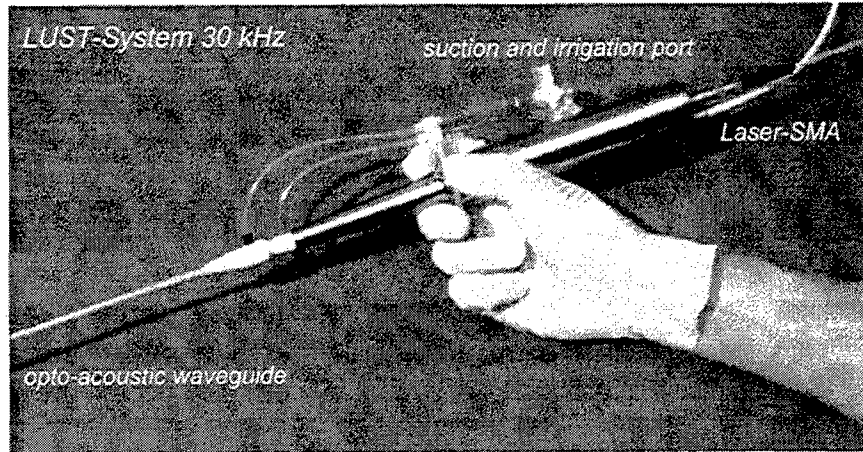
LUST-system for a combined application of Laser and Ultrasound
